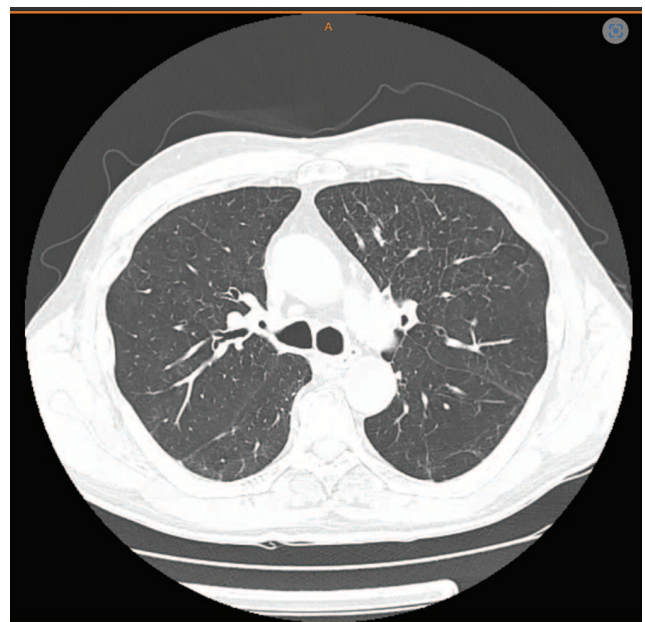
Multislice computed tomography of the chest organs (MSCT OC)
